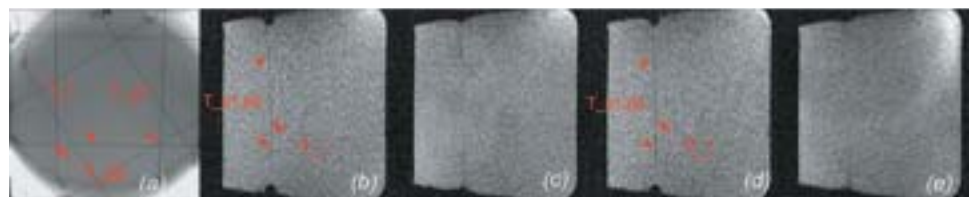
Registration accuracy test. (a): X-ray image with two target points (T_{p1} , T_{p2}) on a target line (T_l). (b) and (c): The target slice calculated without least squares correction and its neighboring slice. Slice warp can be seen here. (d) and (e): The excited target slice with least squares correction and its neighboring slice.
